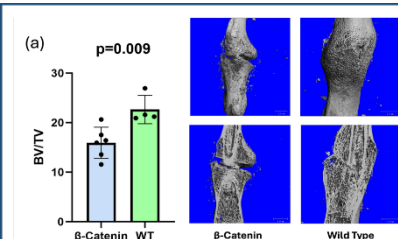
μ CT analysis shows decreased callus mineralization when WNT-signaling is inhibited.
